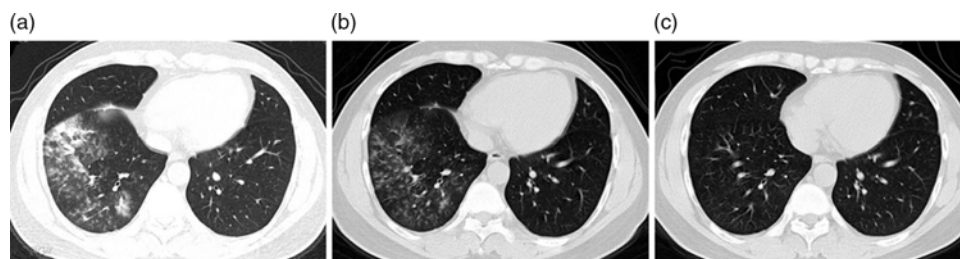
Chest computed tomography (CT) images of a 36-year-old man with a false-positive nucleic acid test result for SARS-CoV-2. The revised diagnosis was community-acquired pneumonia. Panel A: chest CT obtained on February 16 shows large, mixed, ground-glass opacity (GGO) in the right lower lobe with partial consolidation, distribution along with bronchovascular bundles, and a little effusion of the right oblique fissure. Panel B: a CT image obtained on February 21 demonstrates that the lesions in the right lower lobe have been partially absorbed. Panel C: a CT image obtained on February 29 shows that the lesions in the lower right lobe have completely resolved.
